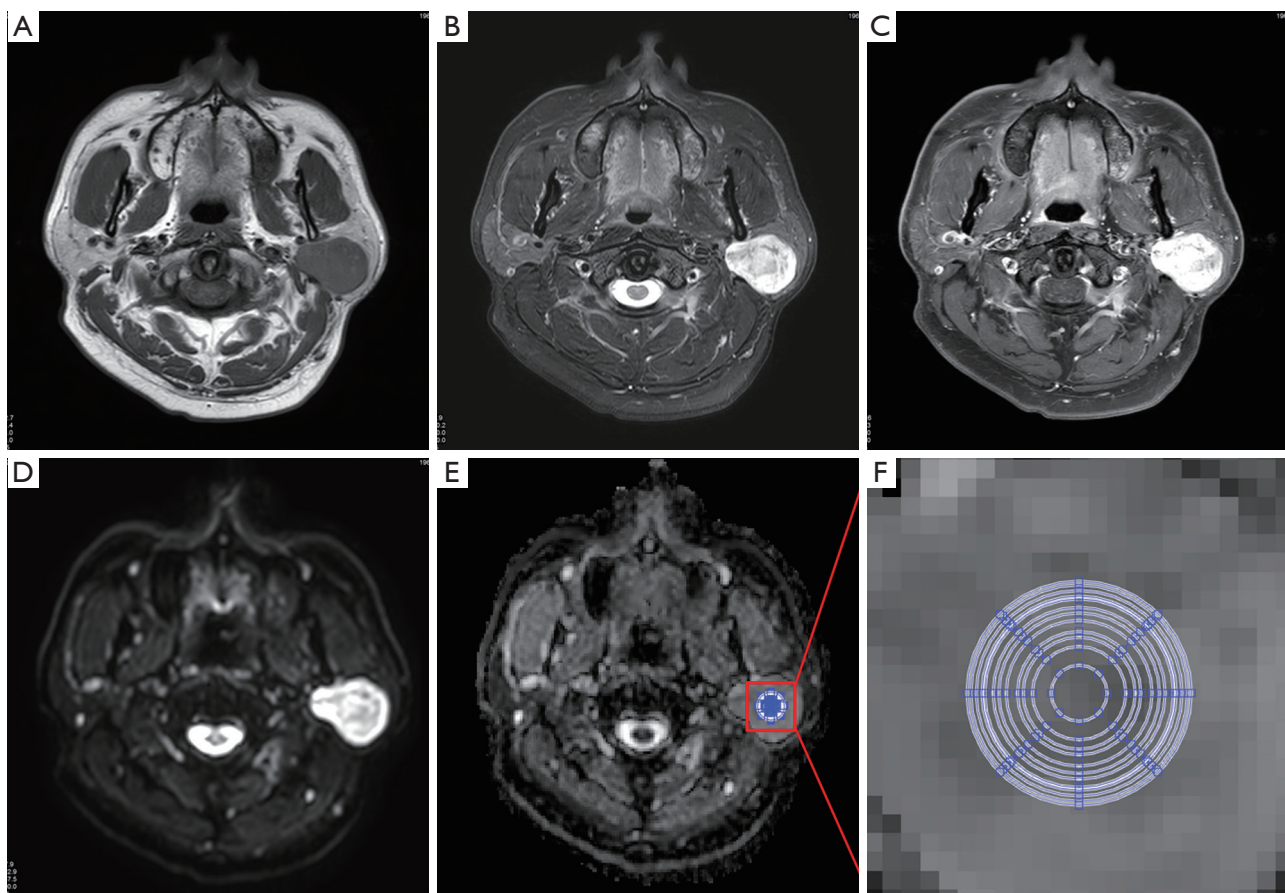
Apparent diffusion coefficient (ADC) measurements of Warthin tumor. (A) Axial T2WI; (B) axial pre-contrast T1-weighted image (T1WI); (C) axial contrast-enhanced T1WI; (D) diffusion weighted image ($b = 1,000 \text{ s/mm}^2$) with clearly demarcated hyperintensity compared with the surrounding and contralateral parotid gland tissues; (E) ADC map; (F) zoomed-in ADC map indicating the 12 concentric round regions of interest (areas: 9, 28, 34, 50, 60, 82, 93, 98, 115, 130, 136, and 149 mm^2) used for mean ADC measurements.
